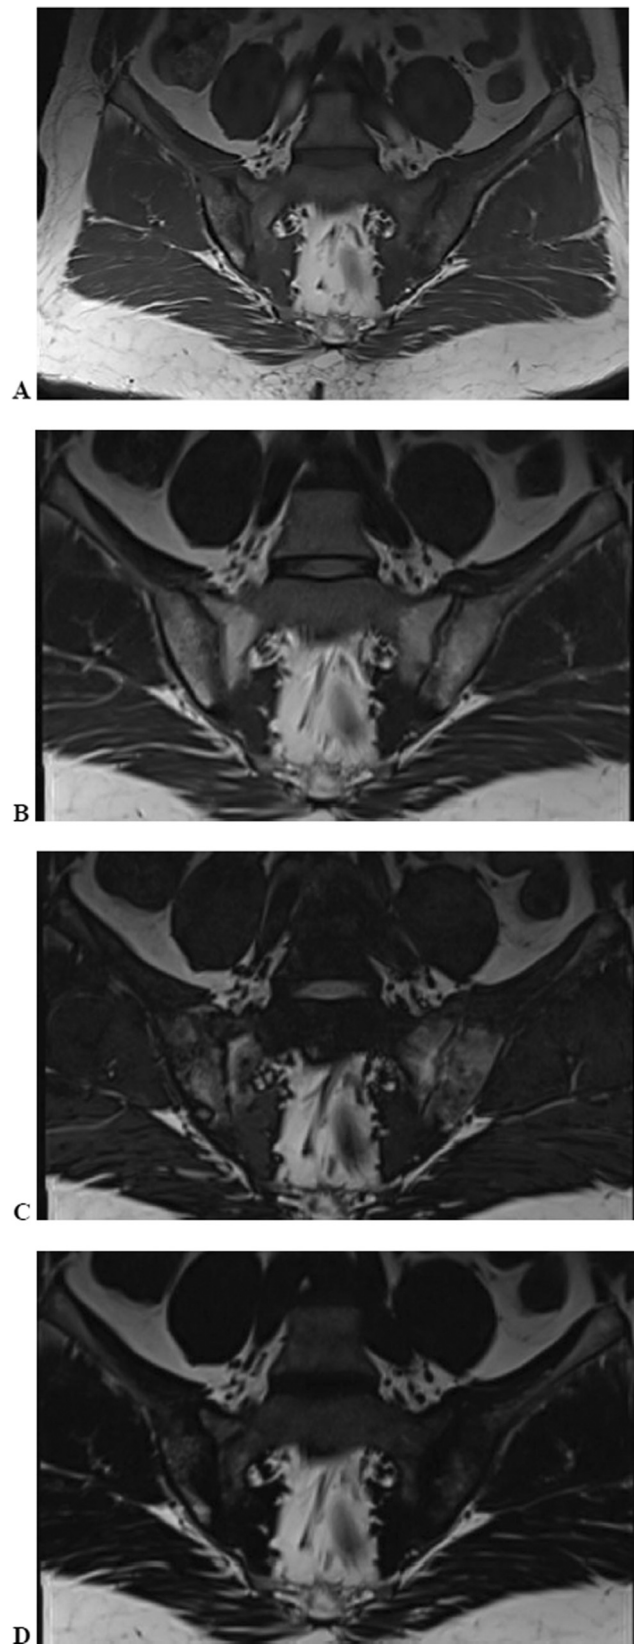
Oblique coronal sections of T1-weighted (A), in-phase (B), opposed-phase (C), and fat only images (D) of subchondral sclerosis in bilateral chronic sacroiliitis.
